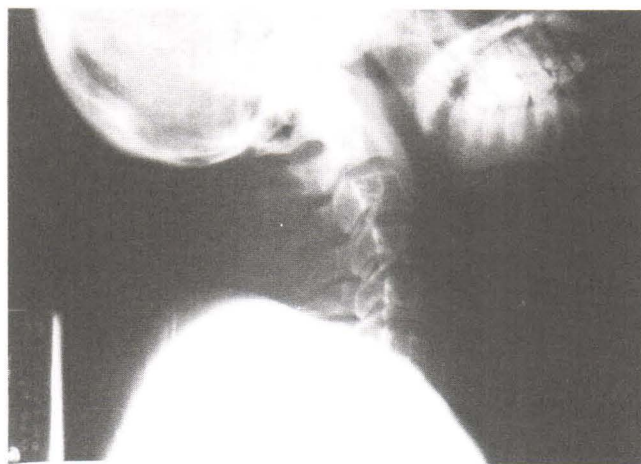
Plain film of cervical spine shows upward displacement of dens of C2 and anterior arch of C1 with mild narrowing of distance between C1 and occiput.
